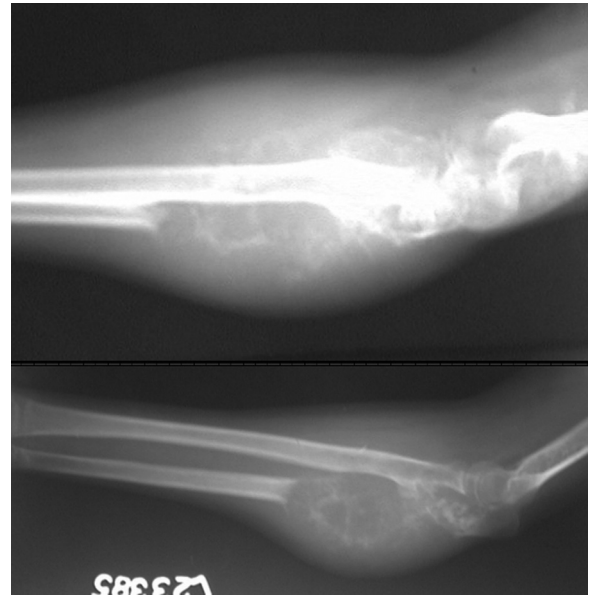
Radiograph forearm and elbow showing extra compartmental osteolytic destruction of ulna with saucerization defect of proximal radius.
